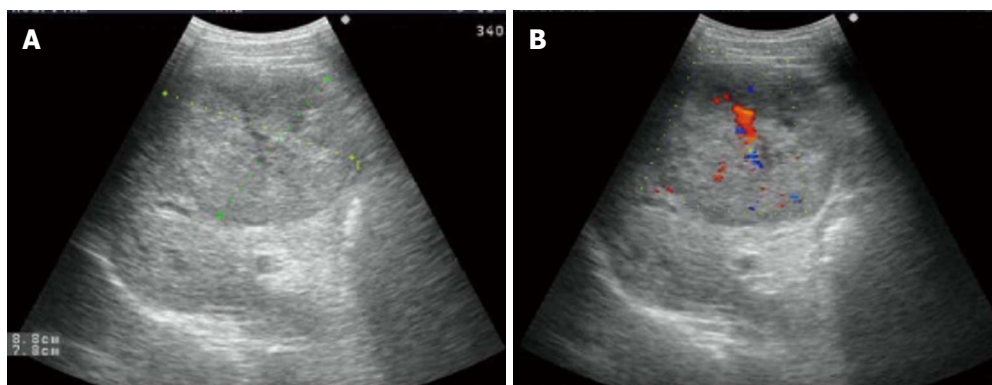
Tumor was hypoechoic on ultrasonography. A: Measuring 8.8 cm × 7.8 cm well-defined hypoechoic mass; B: Color Doppler sonography showing a filiform vascular distribution pattern.
